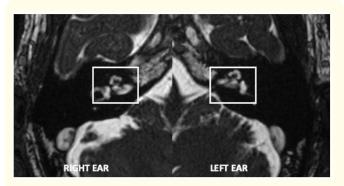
MRI images shows bilateral obliteration of scala tympani of basal turn of cochlea more on right as compared to left with scala vestibuli patent bilaterally.
